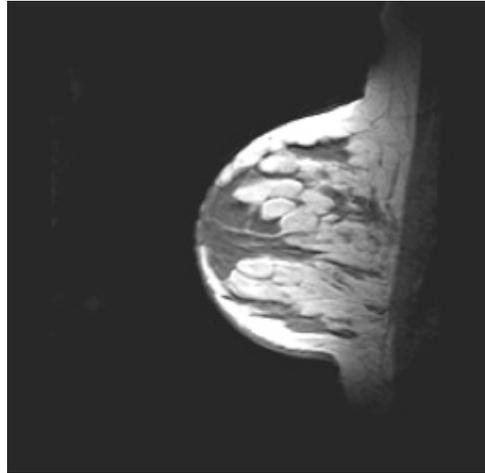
Sagittal MRI of the breast produced using InsightMRI's new coil concept (Obi, 2005). The image shows excellent image quality and spatial resolution, even providing visibility into the chest wall (important to determine the stage of the cancer). As the image above and the other aspects of Aghogho Obi's research indicate, the coil meets the current needs of the MR breast imaging industry. It is now important to integrate the technology into a medical device that meets the needs of different stakeholders involved in the product. The following chapters discuss the approach and methods used to design and validate the housing for two of these coils (for bilateral rather than unilateral breast imaging) and to determine the design specifications of the device, towards future development.
